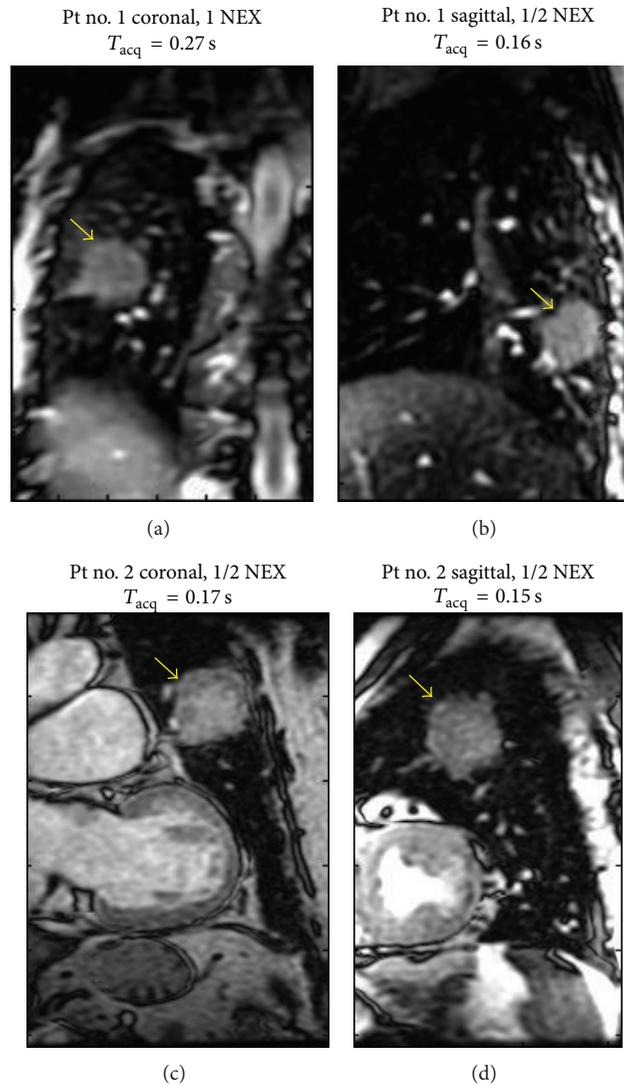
(a) Coronal and (b) sagittal real time MR images acquired from Patient number 1 with an ~40 mm diameter tumor (indicated by the arrows) in the right lower lobe. (c) Coronal and (d) sagittal real-time MR images from Patient number 2 with an ~60 mm diameter tumor in the left upper lobe.
